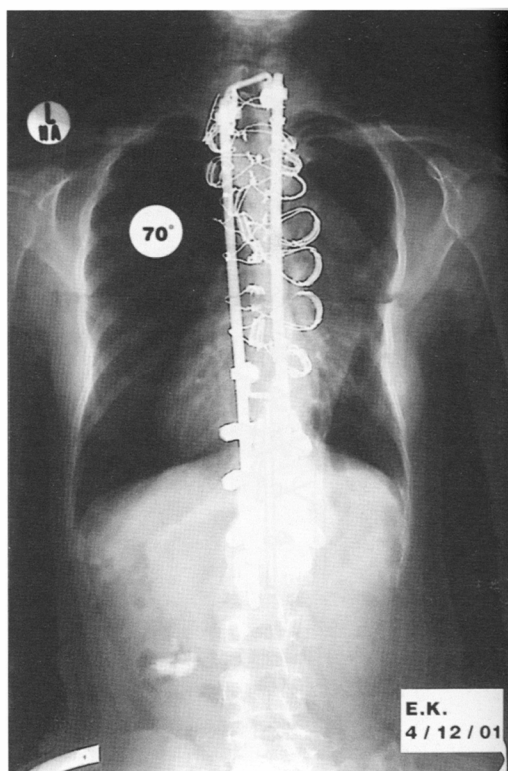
Standing AP radiograph showing a right thoracic idiopathic curve (130°) in a 17-year-old girl who had a 98° correction on the lateral bending film (A).
